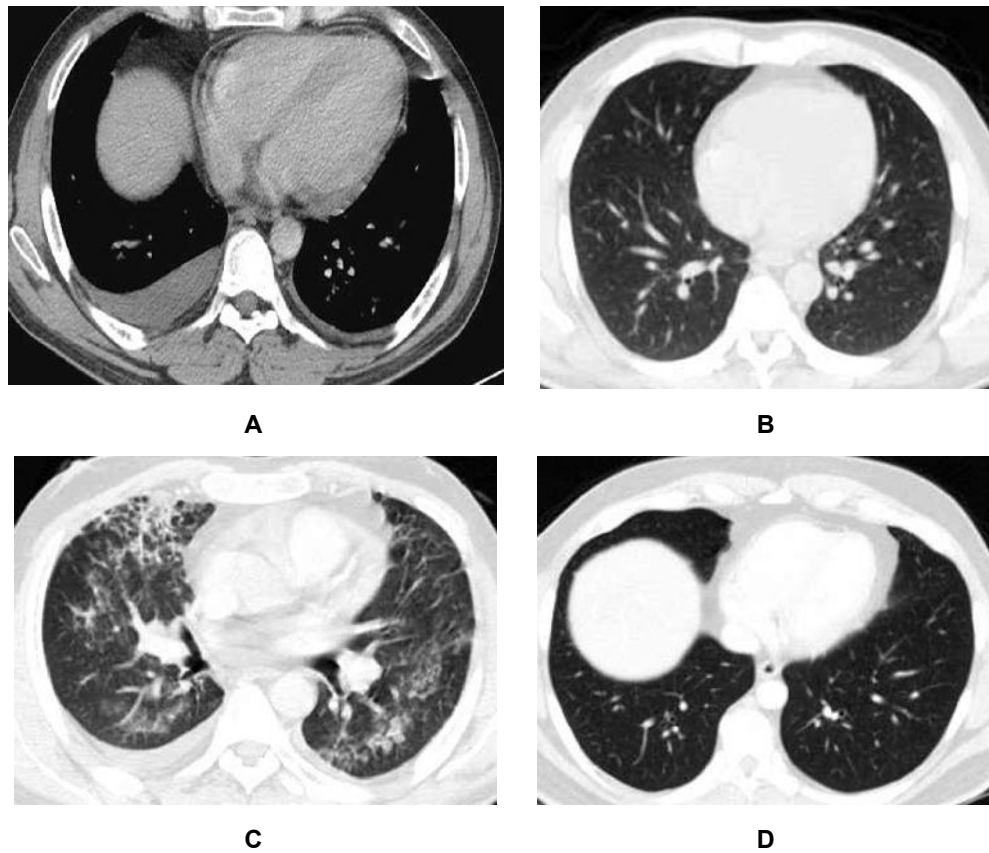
31-year-old male patient with NHL. Patient received 8 cycles of CHOP. Patient complains of dyspnea and cough. Follow up MDCT CT chest. A: Before the start of chemotherapy. B: (mediastinal window) & C: (lung window): Mild right sided pleural effusion with bilateral pulmonary consolidation and ground glass opacities following chemotherapy treatment. D: Marked improvement following termination of chemotherapy
